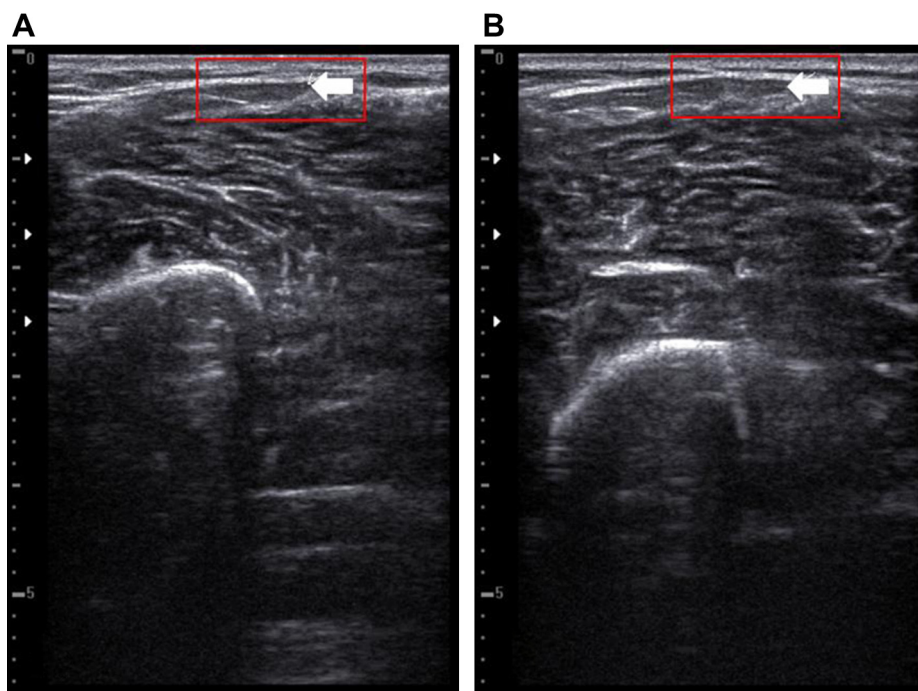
Ultrasound images of the left and right distal biceps brachii aponeurosis. (A) Left distal biceps brachii aponeurosis (arrow); and (B) right distal biceps brachii aponeurosis (arrow).
